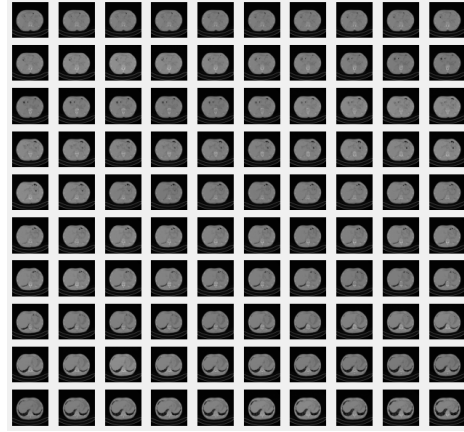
A grid of CT Scans (10x10)
